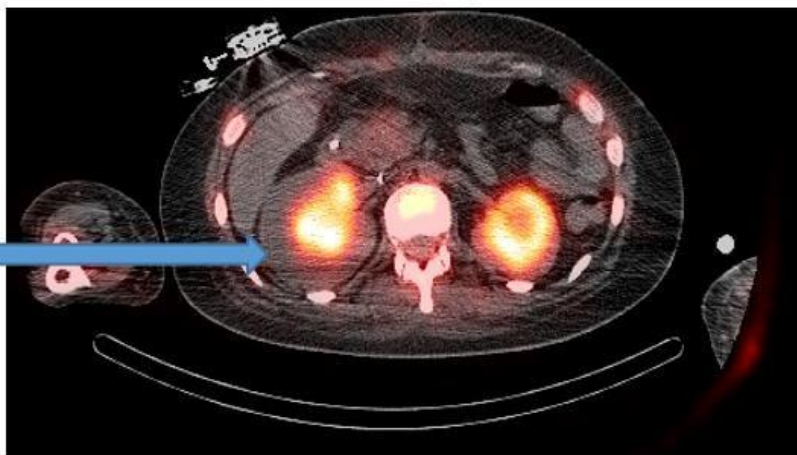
Fused SPECT/CT images demonstrating abnormal cortical retention of radiotracer in bilateral kidneys corresponding to acute tubular necrosis.
